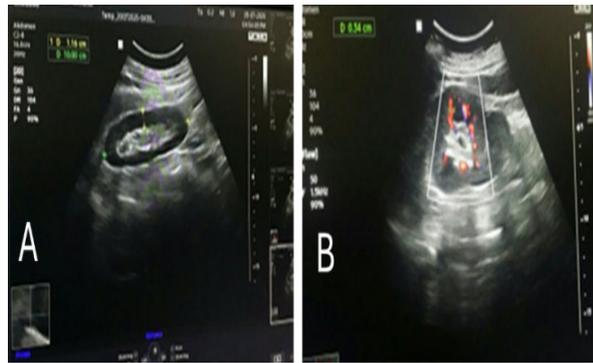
A) Renal ultrasonic measures of renal length and parenchymal thickness; B) Power doppler study of interlobar artery.
